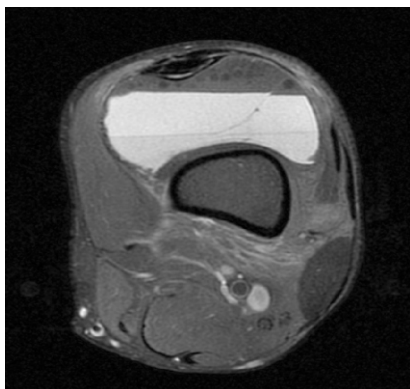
Axial proton density MR image. A double-fluid level is visible. Note the low signal intensity of the highest layer, which is comparable to surrounding fatty tissue. A high-intensity band follows and consists of serum. Cellular parts of blood have sedimented and display an intermediate signal.
